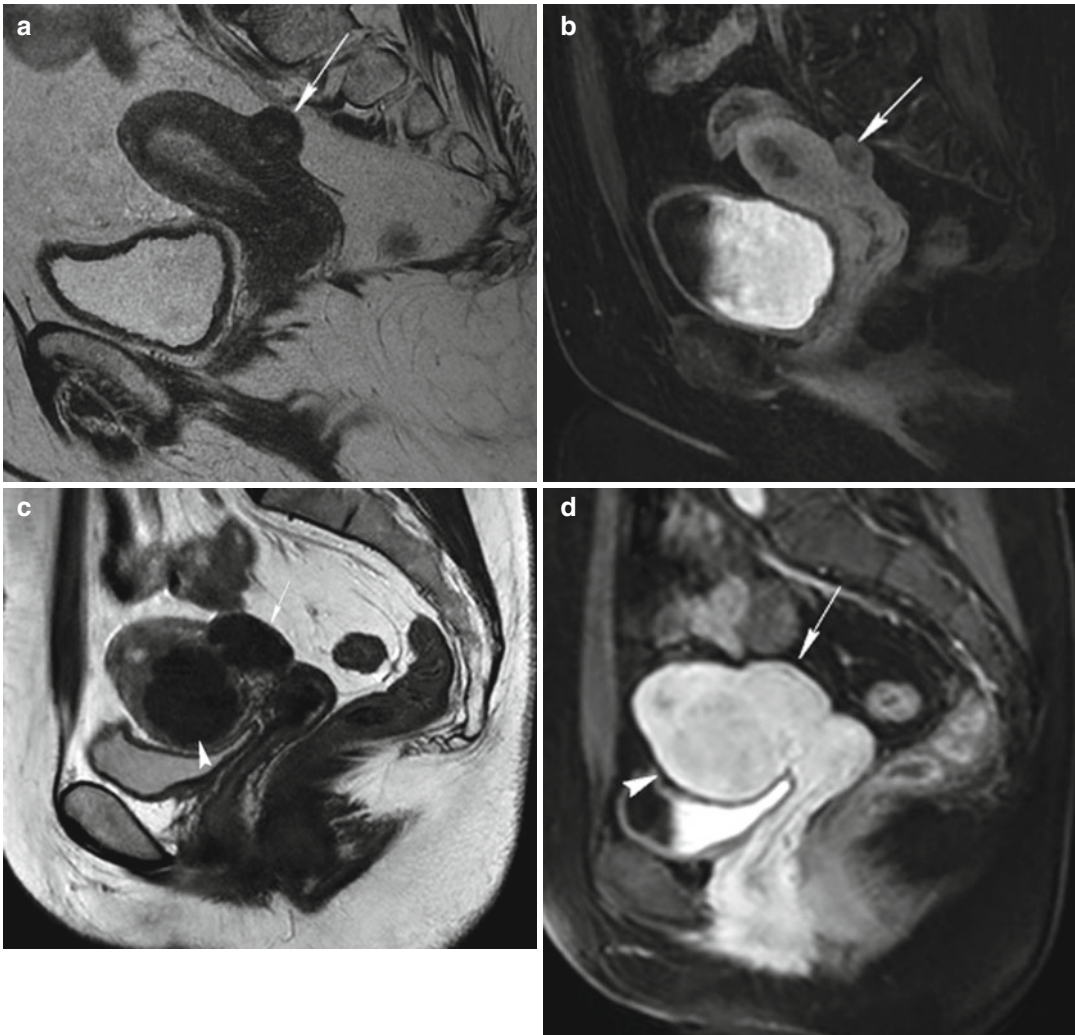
Sessile subserosal fibroids. A little sessile subserosal fibroid on the superior face of the uterus (*arrow*) with heterogeneous low signal intensity on sagittal T2-weighted image (TR 4,500 ms, TE 90 ms) (a) and with low signal enhancement on contrast-enhanced fat-suppressed T1-weighted image (TR 4 ms, TE 2 ms) (b). Another woman (c and d) with a sessile subserosal fibroid on the posterior face of the uterus (*arrow*) and with an intramural fibroid on
